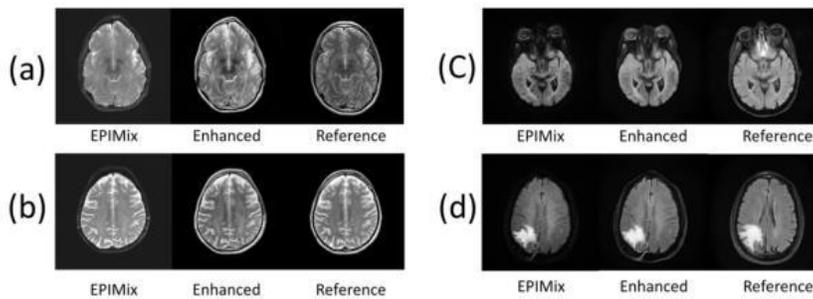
Examples of enhanced images from the test set. (a) (b): T2; (c) (d): T2 FLAIR. Reference images are taken from nearby positions in standard image volumes for visual comparisons. Enhanced and reference images are of 512×512 pixels, while EPIMix images are of 256×256 pixels and enlarged via bicubic interpolation for uniform display.
